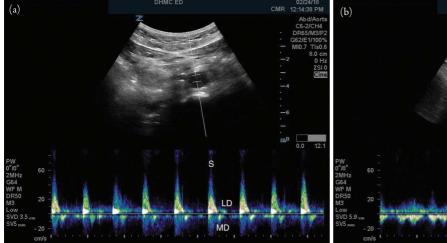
(a) Pulsed-wave Doppler of the aorta. Forward flow in systole (S), reverse flow in mid-diastole (MD), forward flow in late diastole (LD). (b) Pulsed-wave Doppler of the inferior vena cava. Initial shallow upward deflection with atrial contraction (A), and shallow downward deflections with ventricular systole (S) and diastole (D).
